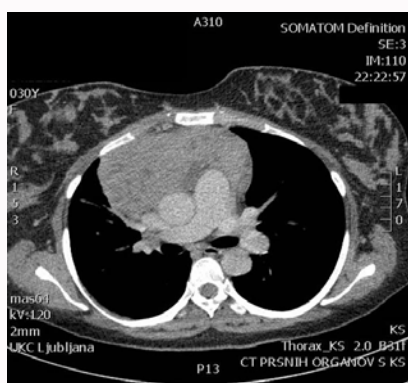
Thoracic CT scan: Mediastinal tumor mass.
